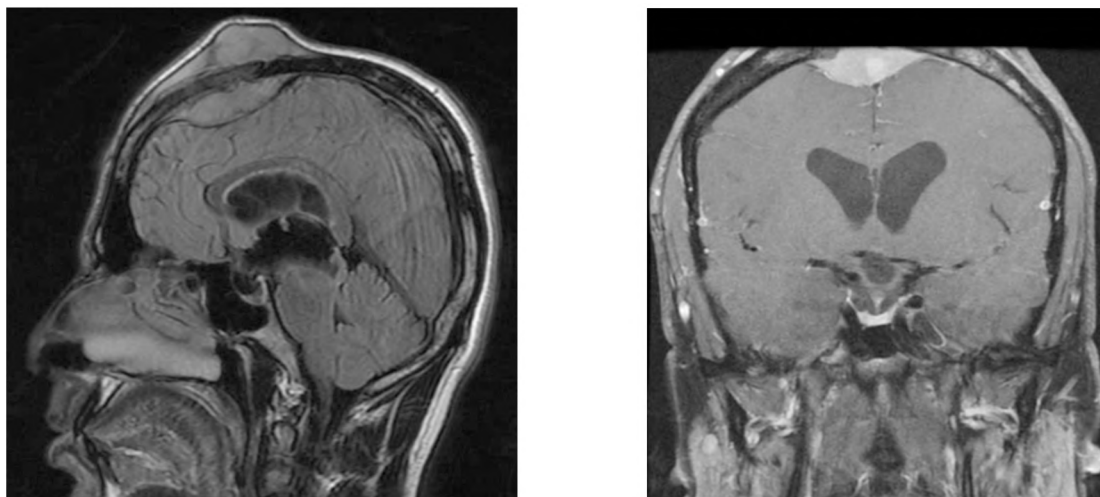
Pre-operative MRI brain without contrast, (Right) pre-operative coronal view, (Left) pre-operative sagittal view MRI brain with contrast showing extra-dural high frontal extra-axial Space occupying lesion (SOL) in the midline (invading the superior sagittal sinus, SSS) with altered structure of the calvaria. Extracranial strong homogenous enhancement SOL.
